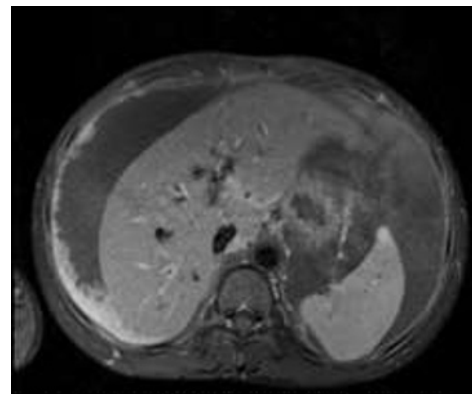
MRI higher in the abdomen demonstrates ascites and enhancing nodular peritoneal thickening.
